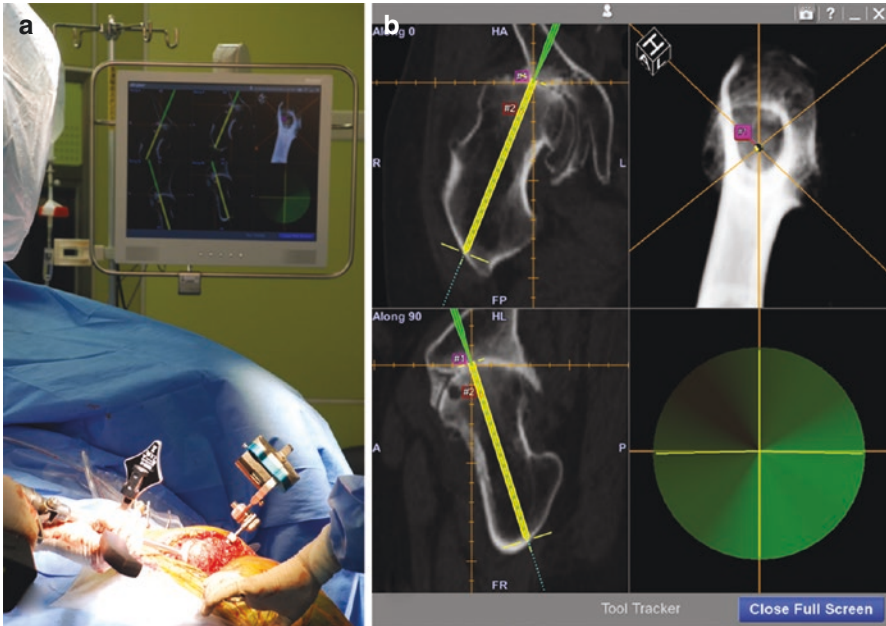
A guidewire is inserted under the guidance of the computed tomography-based navigation system (a). The navigation monitor shows the position and direction of the guidewire relative to the femur (b) (these pictures were agreed by the patient for publication)
